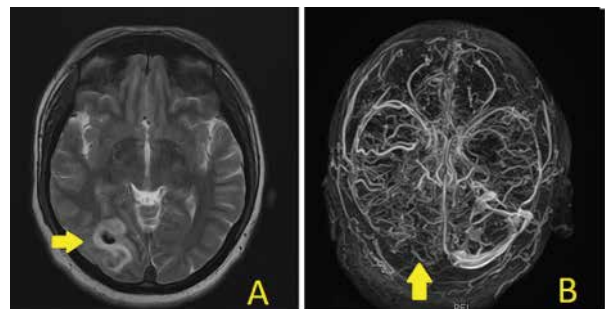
Magnetic Resonance Imaging (MRI) of brain showing hemorrhagic infarct in the right parietal lobe (yellow arrow in panel A). Magnetic resonance venogram showing non-visualization of right transverse sinus (yellow arrow in panel B).
